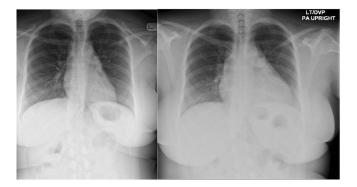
Chest X-ray on the left is from 2 years prior to presentation and chest X-ray on the right is at time of presentation. Both demonstrate left clavicular destruction.
